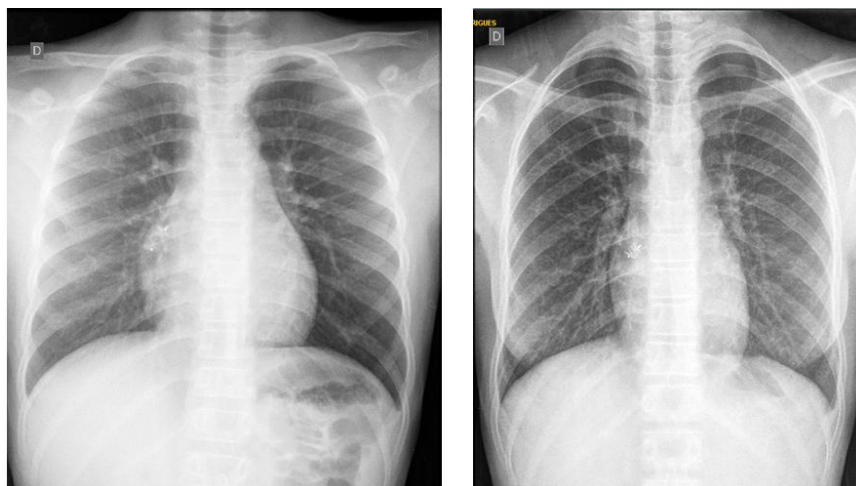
Chest X-rays before (left) and 5 years after (right) coronary-cavity fistula occlusion, highlighting the decrease in heart size (slightly enlarged before procedure).
